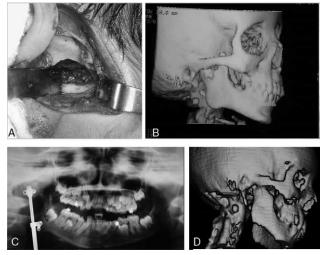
(A) Intraoperatory GAP arthroplasty. (B) Computed tomography scan with temporomandibular joint ankylosis and coronoid hyperplasia. (C) Panoramic x-ray, showing 20 mm of distraction osteogenesis. (D) Computed tomography scan after GAP arthroplasty and distraction osteogenesis (patient 2).
